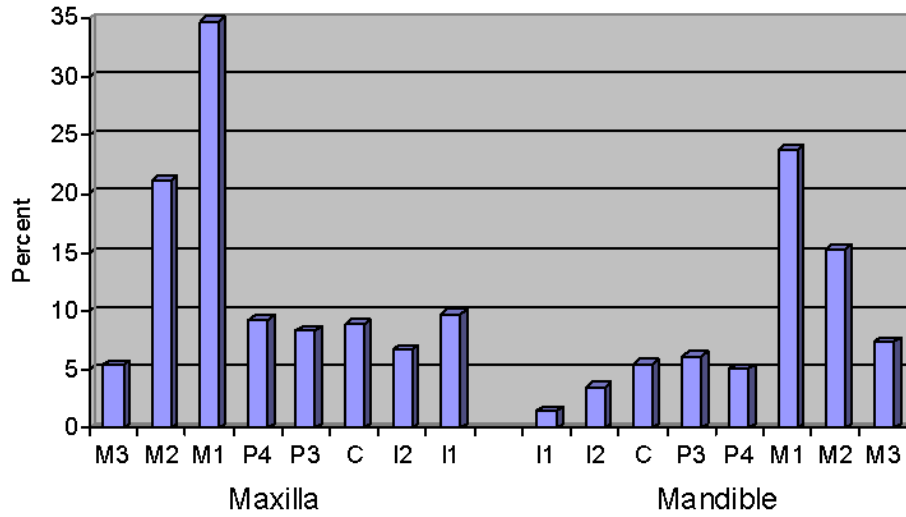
Frequencies of Periapical Abscesses in Maxillary and Mandibular Dentitions for CA-CCO-18/548.
